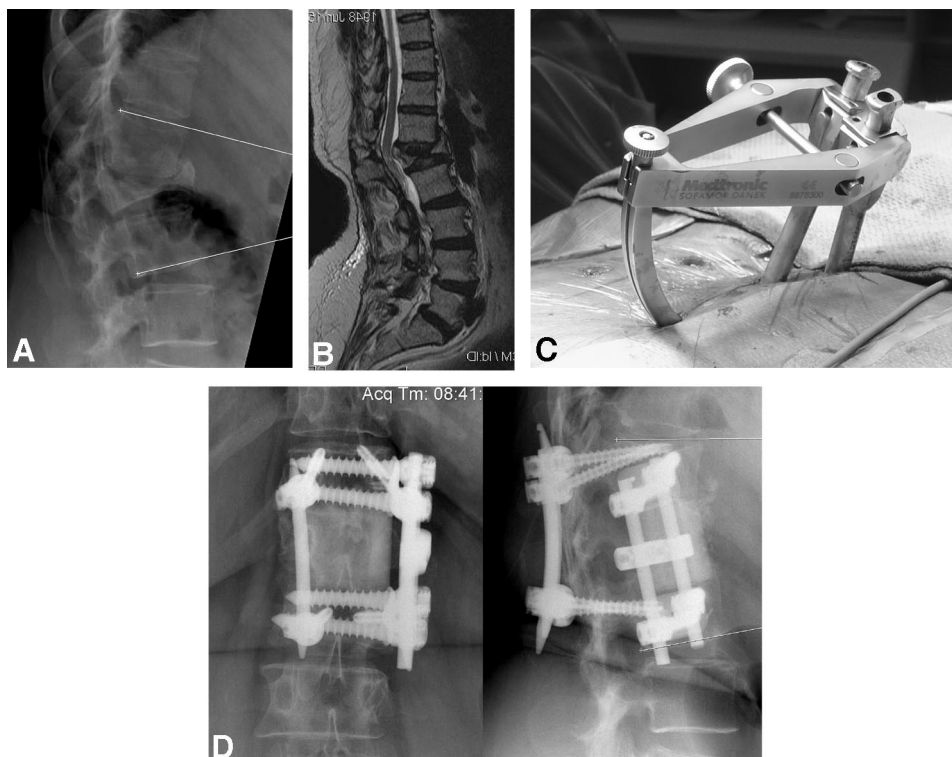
A, Upright preoperative lateral radiograph from a 60-year-old woman with mechanical back pain, progressive kyphotic deformity (a 32° kyphosis from T12 to L2 is demonstrated) 9 months following a burst fracture. B, Preoperative sagittal T2 MRI demonstrating central contact of the adjacent discs. CT confirmed a nonunion of the vertebral body. C, Intraoperative picture demonstrating percutaneous passage of a rod from cephalad (T12) to caudal (L2). Because of this patient's documented osteopenia, percutaneous augmentation of the posterior tension band and anterior construct was performed following a L1 corpectomy and reconstruction. The anterior procedure was performed using a mini-open (14-cm incision) muscle-splitting anterior retroperitoneal-retropleural approach. D, Six-month upright postoperative radiographs demonstrating the final construct. Compared with the intraoperative radiographs, the patient had an initial (in-hospital) 5° loss of correction, which has remained stable.
